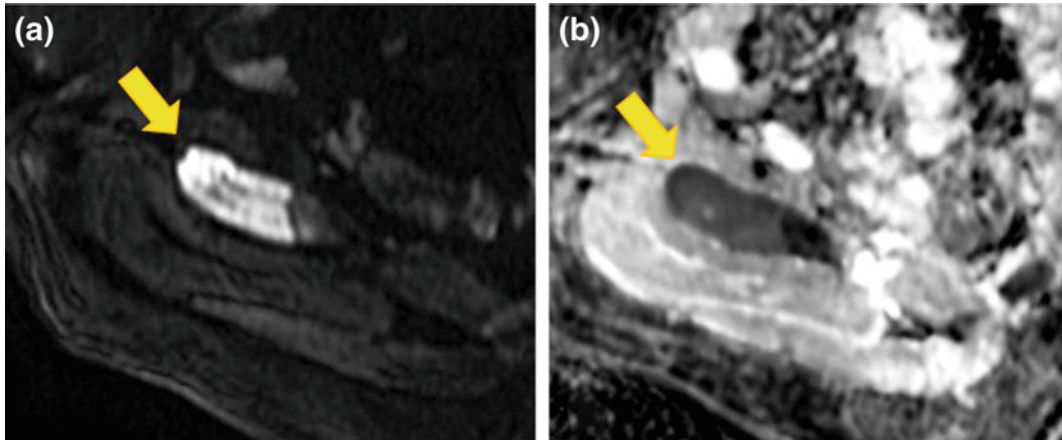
a Painful right iliac bone metastasis with evidence of water diffusion restriction at DWI imaging ($b = 1000 \text{ s/mm}^2$). b ADC map hypointensity confirms DWI detection
